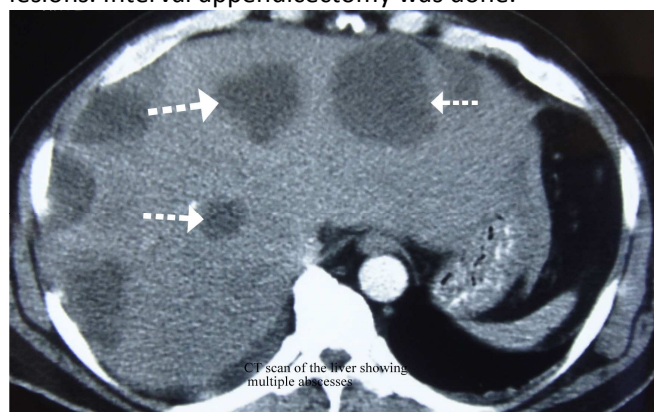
Computed tomography (CT) abdomen showing multiple hypodense lesions in the liver.
